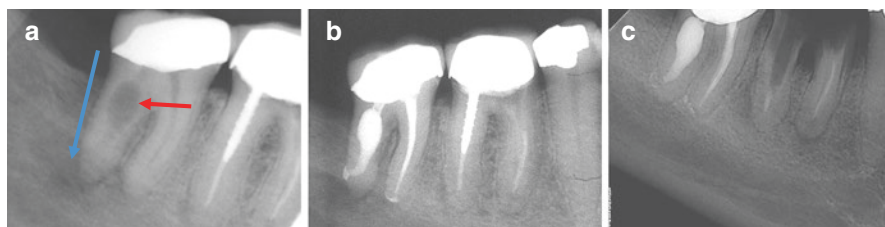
Example of internal root resorption with endo-perio lesion, tooth #31, managed with nonsurgical root canal treatment. (a) The resorptive defect is visualized (red arrow), and distal periodontal attachment loss extended to the apex of the distal root (blue arrow). (b) The immediate post-fill radiograph. (c) 18-month posttreatment evaluation radiograph. Note excellent healing of the distal endo-perio lesion associated with #31, although #30 is now non-restorable for unrelated reasons
